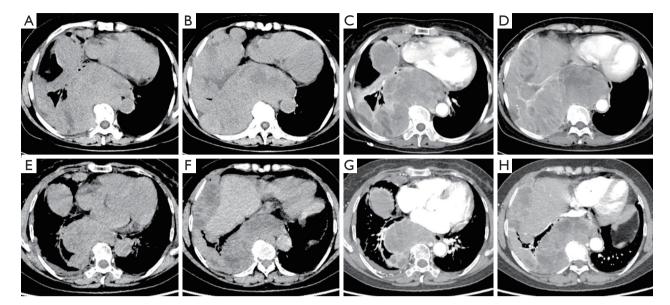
Chest CT of the patient with pleural metastases before treatment and after targeted therapy. (A-D) Three years after surgery (October 2021) review chest CT: (A,B) chest CT plain scan revealed multiple masses of various sizes in the paravertebral posterior mediastinum and the right pleura, extending to the abdominal cavity; (C,D) chest CT enhanced scan showed the mass with obvious heterogeneous enhancement. (E-H) After targeted therapy (January 2022), the plain and enhanced chest CT scan showed that multiple masses in the paravertebral posterior mediastinum and right pleura had shrunk compared to before. CT, computed tomography.
